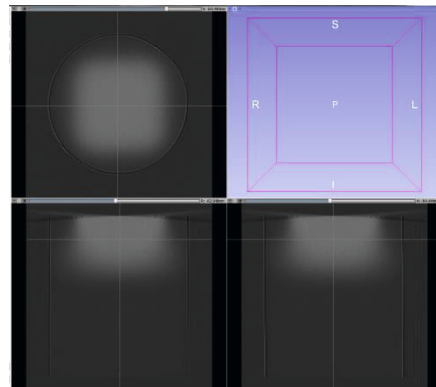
Screenshot showing slices through the optical CT data of a  $6 \times 6$  cm<sup>2</sup>, 300 MU 12 MeV electron beam gel dosimeter irradiation
